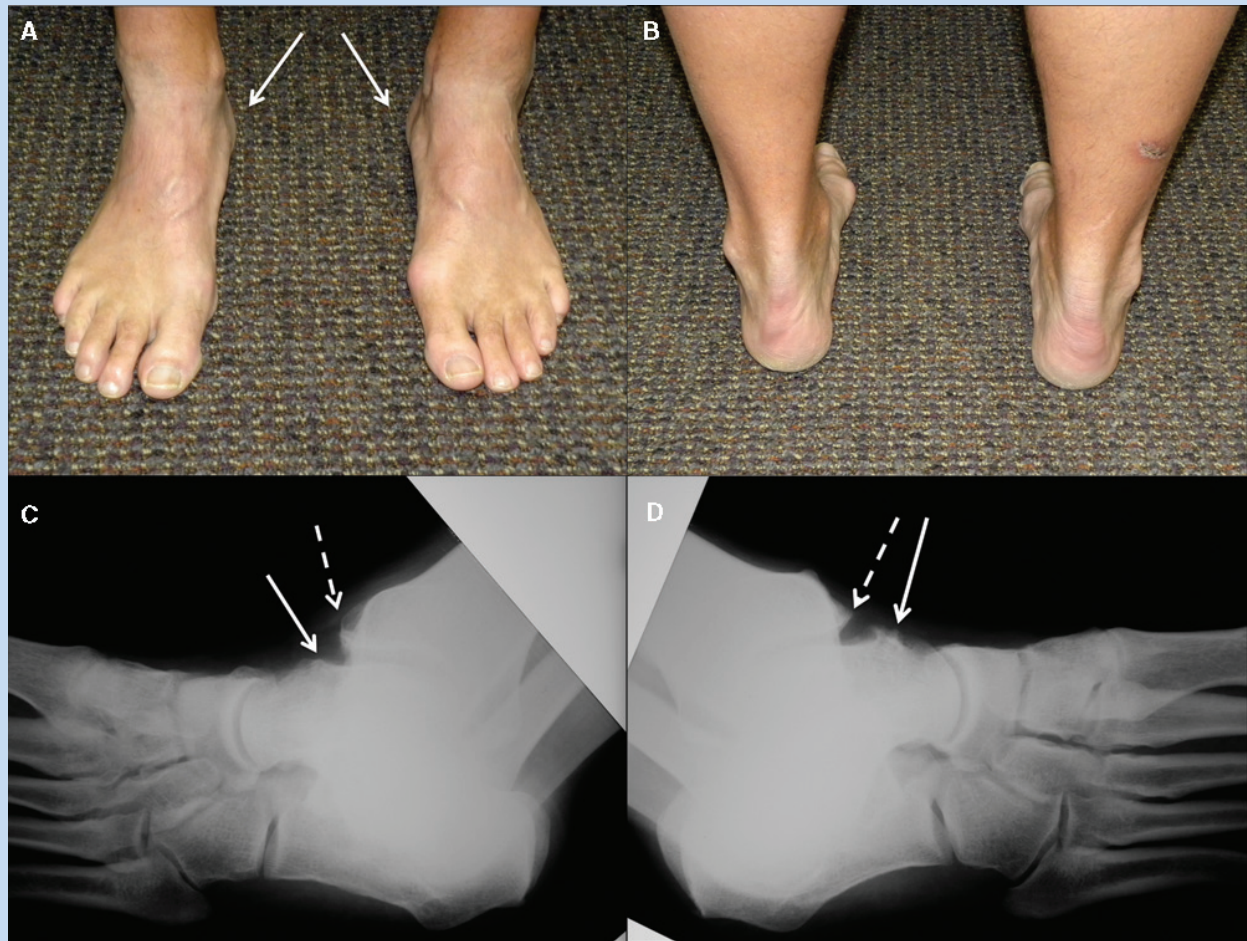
A, middle-aged distance runner with moderate subtle cavus feet—note the peek-a-boo heels bilaterally (arrows); B, rear view showing typical heel varus bilaterally; C, oblique radiograph of the left foot—note the talar and tibial impingement spurs (solid arrow and broken arrow, respectively); D, oblique radiograph of the right foot—note the medial impingement spurs on the talus and tibia (solid arrow and broken arrow, respectively).
